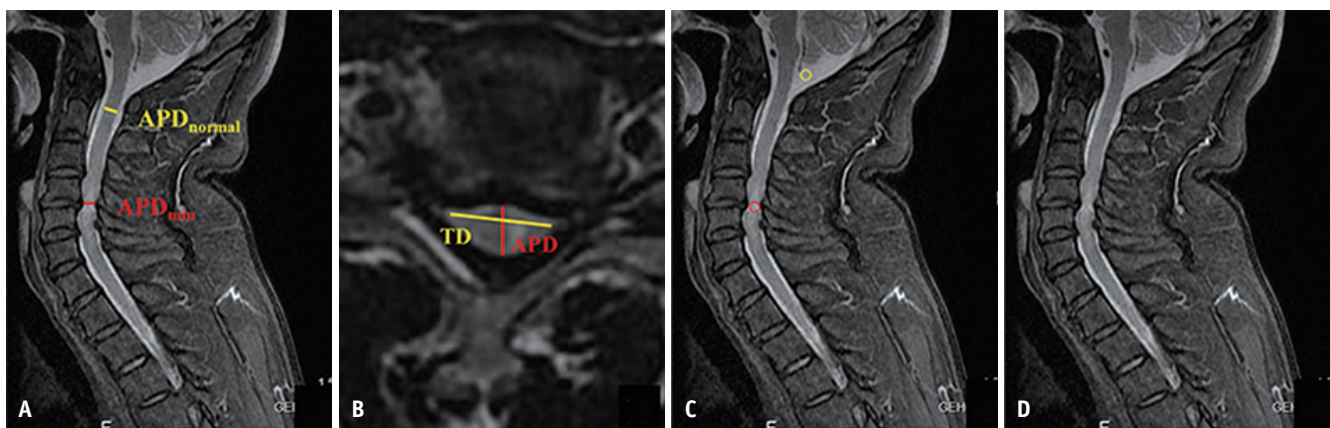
Preoperative T2-weight MRI measurements.
